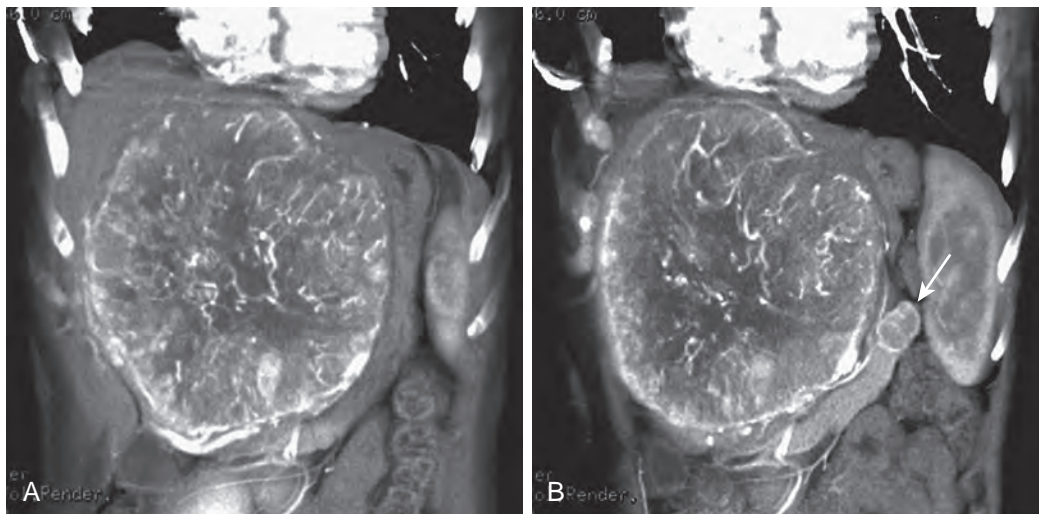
Hypervascular liver metastases on CT. A and B. A dominant, strikingly hypervascular mass from metastatic leptomeningeal hemangiopericytoma is demonstrated on these two coronal volume rendered images. Arrow, Pancreatic tail metastasis.
